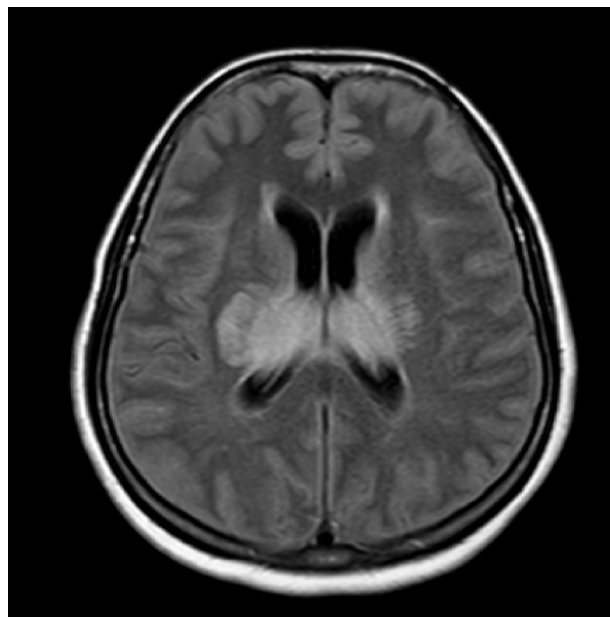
Axial T2-weighted MRI demonstrating symmetrical thalamic involvement, consistent with the "doughnut sign" in dengue encephalitis
